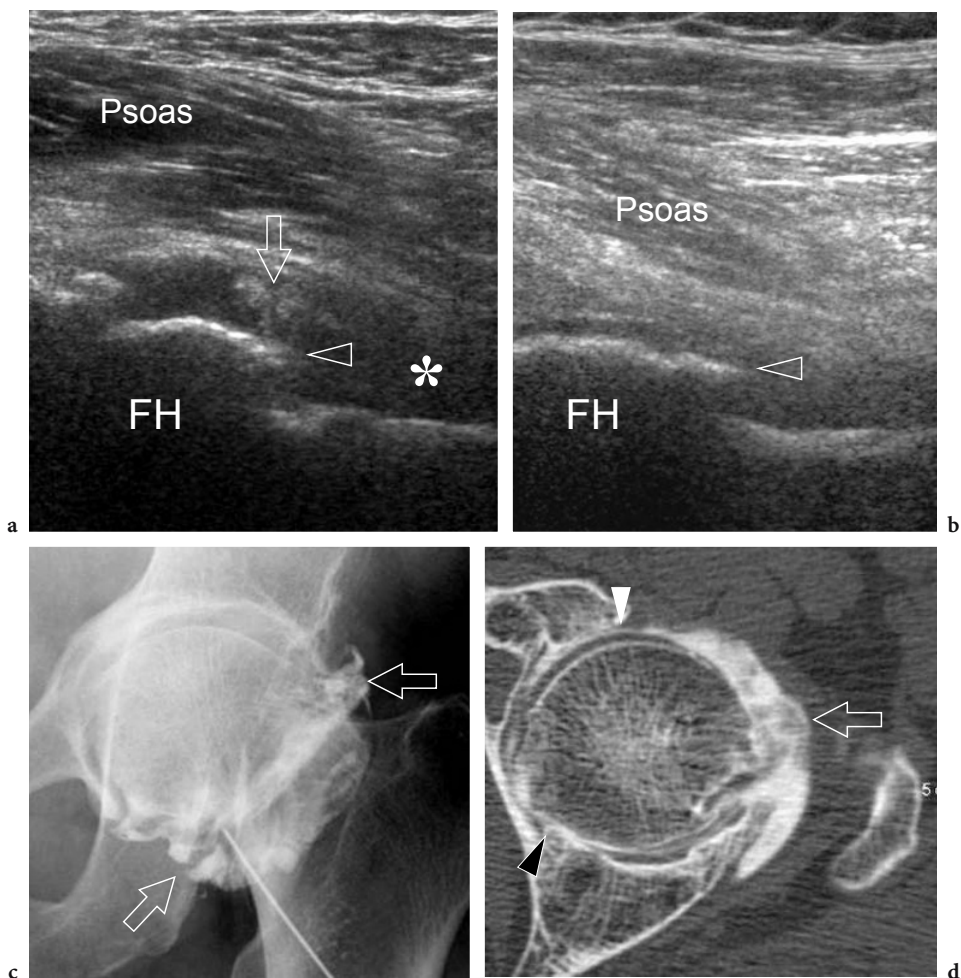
Intra-articular synovial hypertrophy in a woman with posterior osteoarthritis of the left hip. a,b Transverse oblique 12–5 MHz US images over the anterior hip show a fluid effusion (*asterisk*) filling the anterior synovial recess. Synovium hypertrophy (*arrow*) can be appreciated as echogenic folds projecting into the joint cavity. Note the anterior osteophytes (*arrowhead*) appearing as pointed hyperechoic projections between the head (*FH*) and neck of the femur. c Arthrographic anteroposterior image displays contrast dye filling the synovial cavity. Multiple filling defects (*open arrows*) are due to the hypertrophied synovial folds developing inside the joint cavity. d Transverse CT-arthrographic image confirms the presence of hypertrophied synovium (*arrow*) within the joint. Note that the anterior cartilage of the femoral head is normal (*white arrowhead*), in contrast to the posteromedial cartilage (*black arrowhead*) which appears markedly thinned
